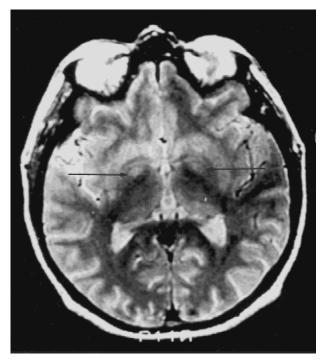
Axial T2-weighted MRI showing bilateral hypersignal lesion in the globus pallidus.
